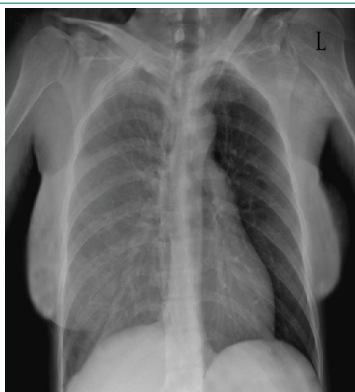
Chest x-ray of the 28-years old female with thoracic endometriosis demonstrated pleural effusion on the right side.
